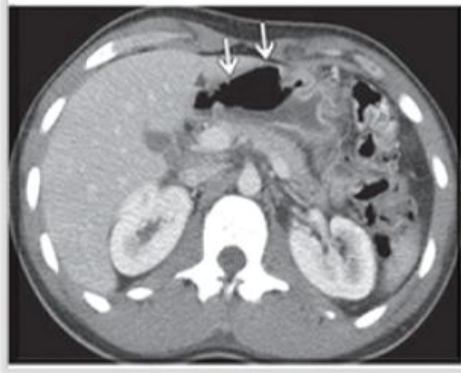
Axial contrast-enhanced CT image of the distal stomach reveals that the body is primarily involved, and the antrum is relatively spared (arrows) Source: Radiographics (2009).
